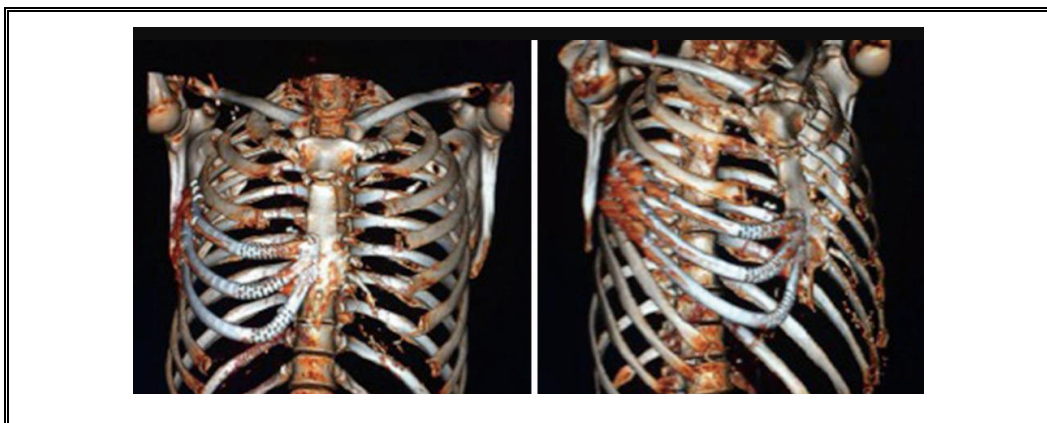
Three Dimensional (3D) Computed Tomography (CT) of sternum reconstructed with 3D titanium-printed implant.
